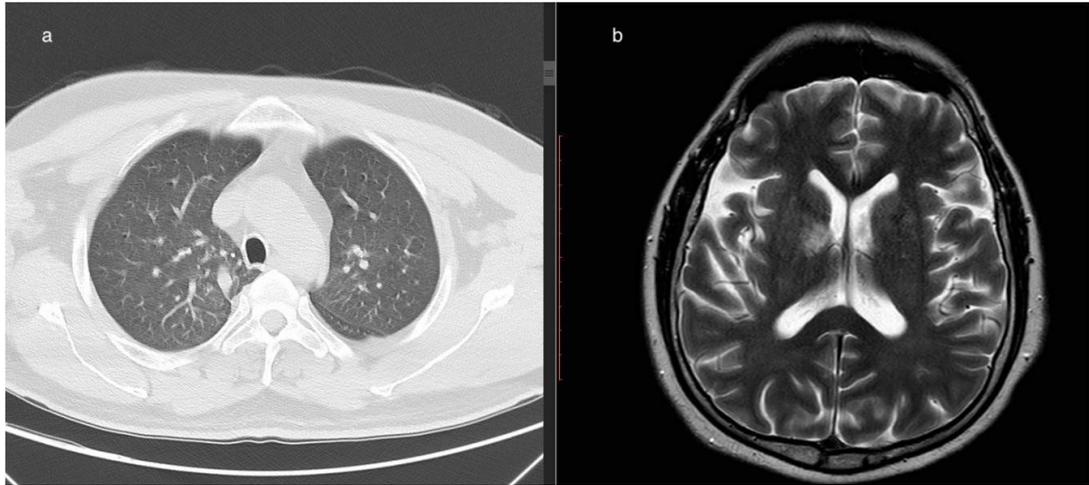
a Thoracic computed tomography at discharge, b Control cerebral MRI examination showed partial regression in the thalamic region ischemic infarction
